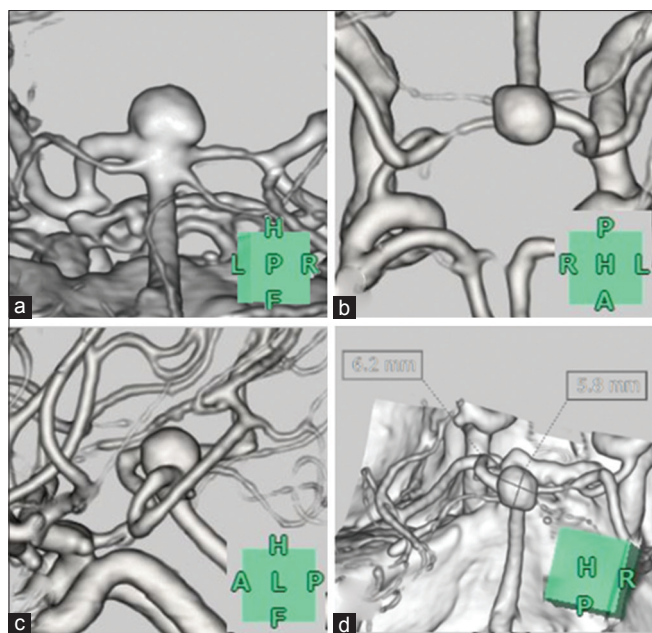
Computed tomography angiography showing a saccular aneurysm at the basilar tip measuring 6.2 mm × 5.8 mm. (a) Posterior view; (b) head view; (c) left view; (d) head view
